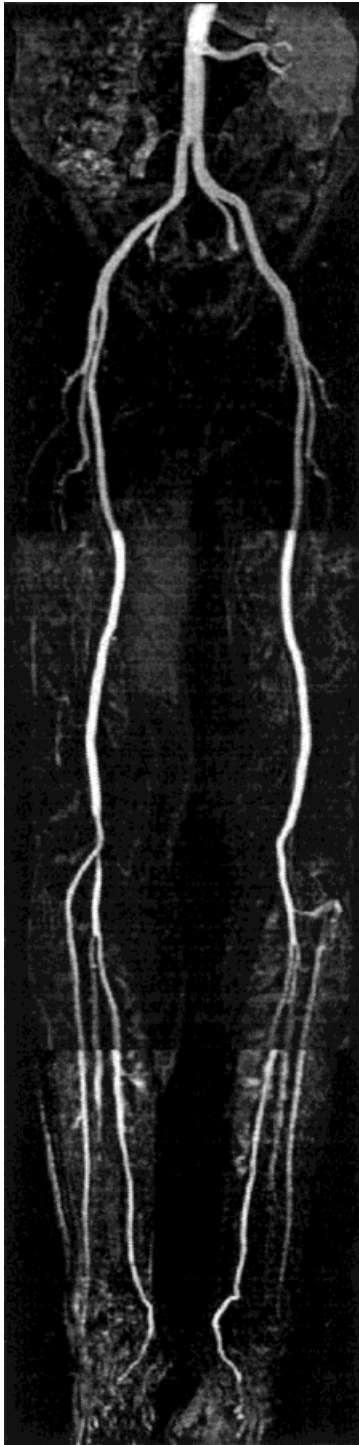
Bolus-chase peripheral MRA obtained with an 11 second scan delay, 58 second bolus duration, 0.7 ml/sec Gd injection rate for a Gd dose of 40 ml and a scan time of 30 seconds per station. These parameters were based on ultrasound bolus timing measurements of aorta peak time = 26 seconds, femoral artery time = 33 seconds, and popliteal artery time = 38 seconds. Note the optimum arterial phase of the bolus at all three stations.
